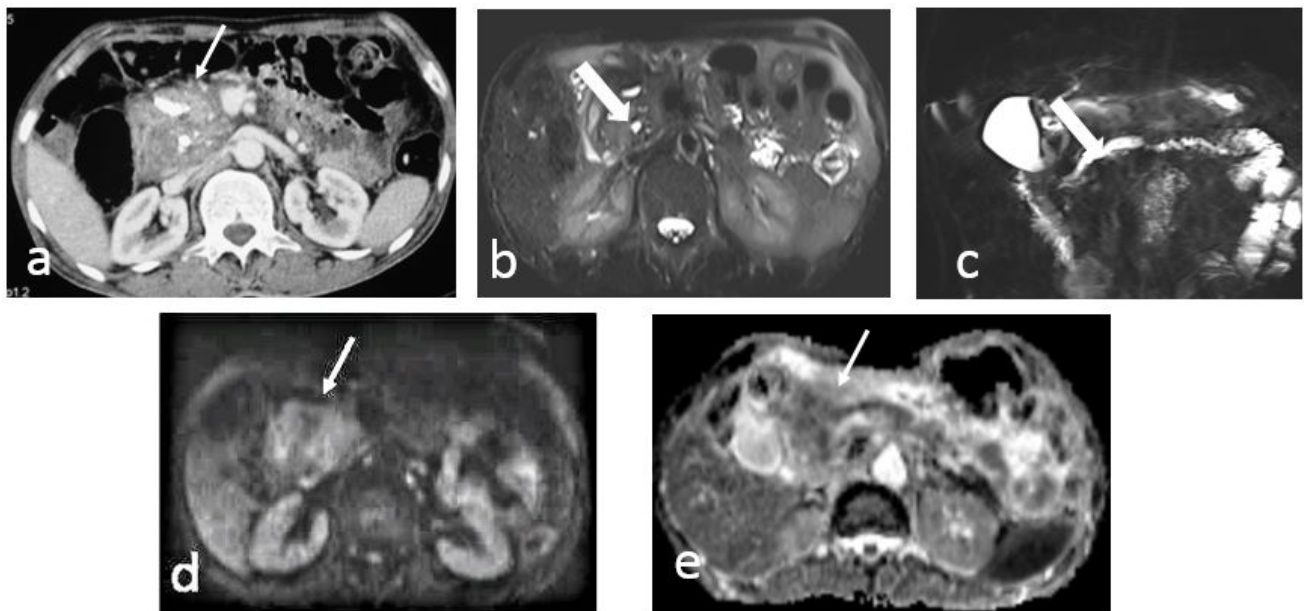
Axial contrast enhanced CT (a) in a patient with CCP shows a heterogeneous mass lesion in the head of pancreas (thin arrow) with multiple calcific foci. Heavily T2W MR images (b,c) show the dilated tortuous MPD coursing through the mass lesion (thick arrow) which is called as duct penetrating sign. Diffusion weighted image (d) and ADC map (e) shows that there is no significant diffusion restriction in the mass. Based on the above findings diagnosis of mass forming chronic pancreatitis was made. Patient was later subjected to EUS guided sampling which confirmed the diagnosis.
